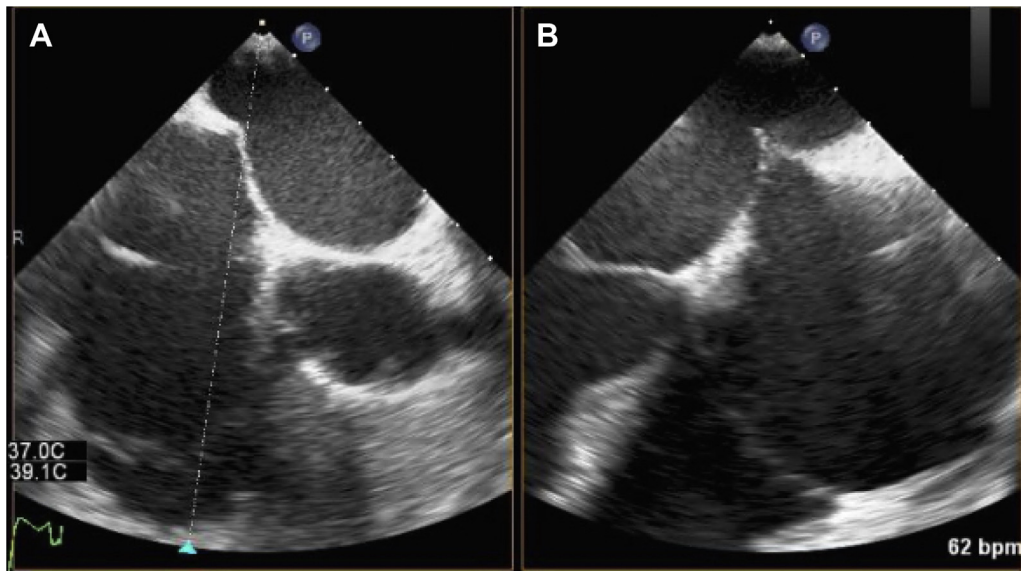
Transesophageal echocardiography image: transseptal puncture. A: 45° image, showing anterior/posterior orientation. B: 135° image showing superior/inferior orientation. This transseptal puncture was posterior and mid atrial septum, a good place for transseptal puncture.
